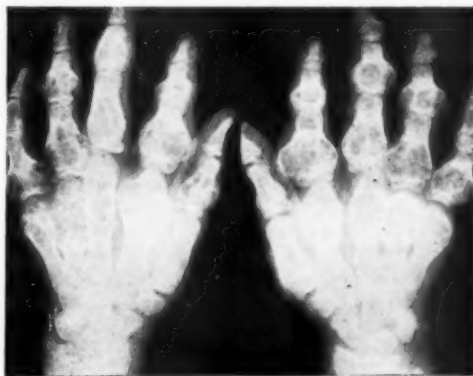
Roentgenogram of the hands taken in 1939. Comparison with a more recent film (Fig. 3) shows little change in appearance of the lesions over a five-year period.
